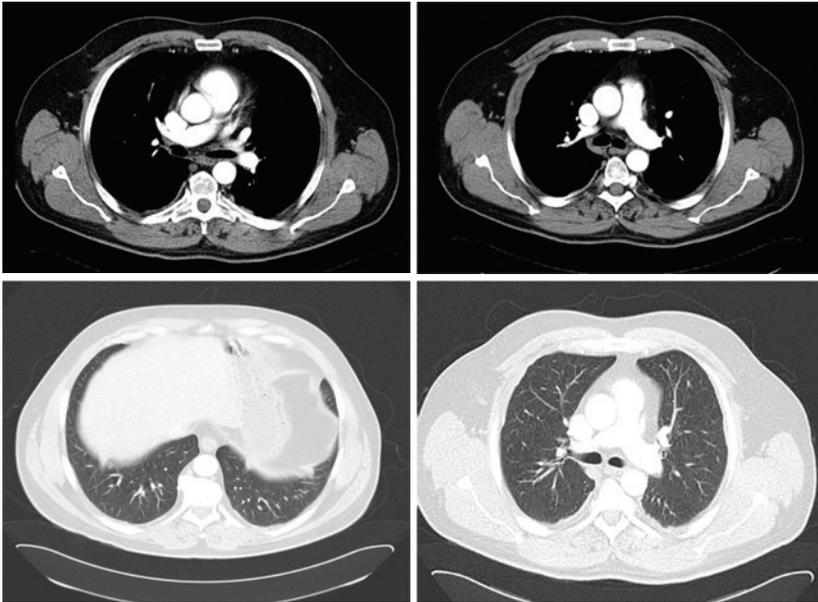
Slices from CT of the thorax.
